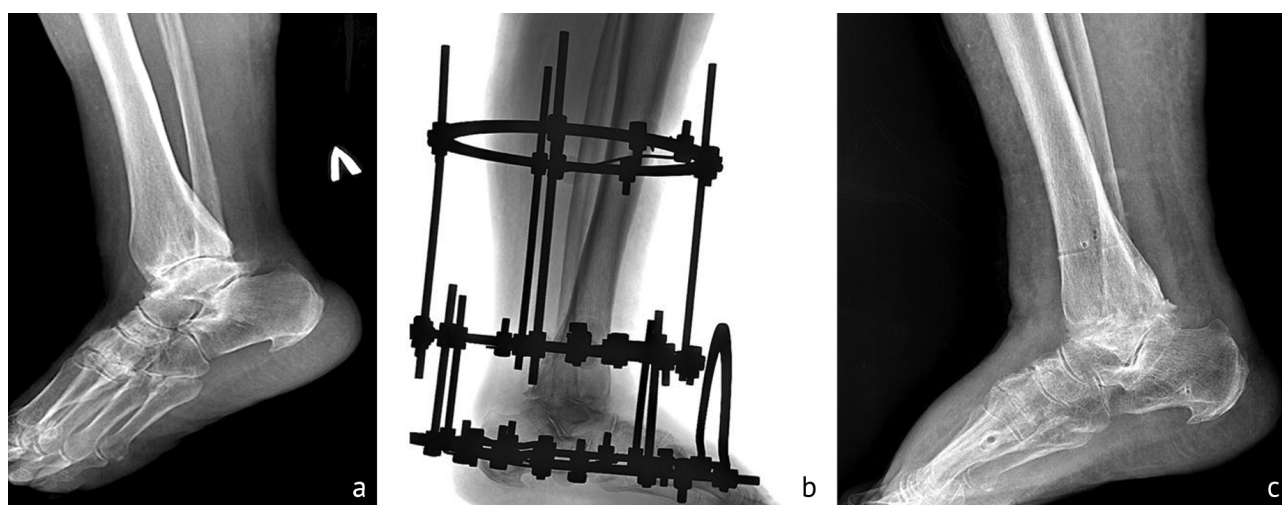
Radiographs of the left ankle of a 60-year-old patient (lateral views): dynamics of the arthrodesis process with Ilizarov external fixation before surgery (a), 1st day after surgery (b), 3rd month after surgery (c)
